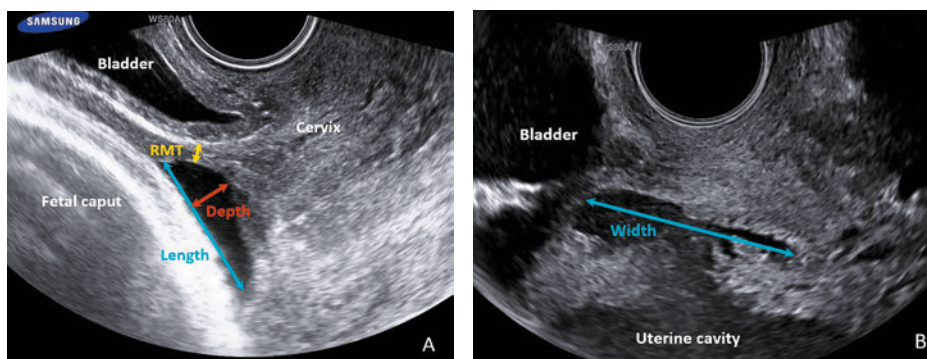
Niche measurements in pregnancy according to Jordans et al.¹¹ using transvaginal ultrasound. An example of measurement in 3rd trimester of pregnancy. A, Measurements in the sagittal plane: length and depth of the niche, and RMT. B, Measurement in the transversal plane: width of the niche. RMT, residual myometrial thickness
